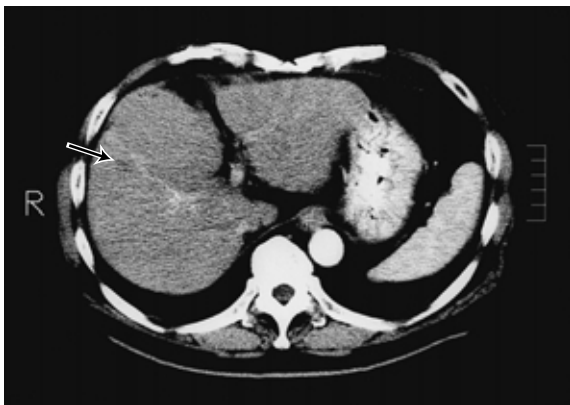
Case 1. An early conventional CT image
